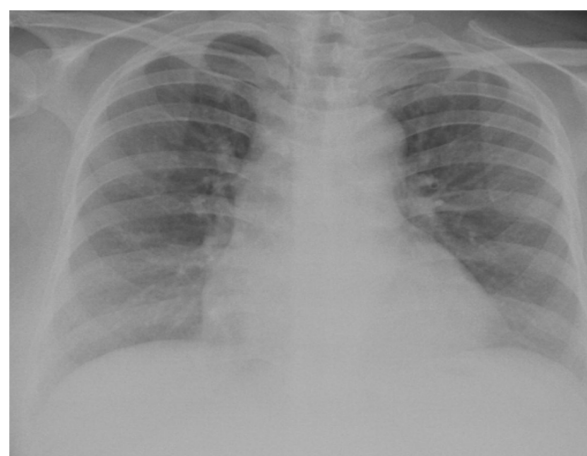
Chest radiograph (posteroanterior view) on admission, showing increased and hazy bronchovascular markings, a positive hilar haze sign, and a cardiothoracic ratio greater than 50%, consistent with an early pulmonary edema pattern.
